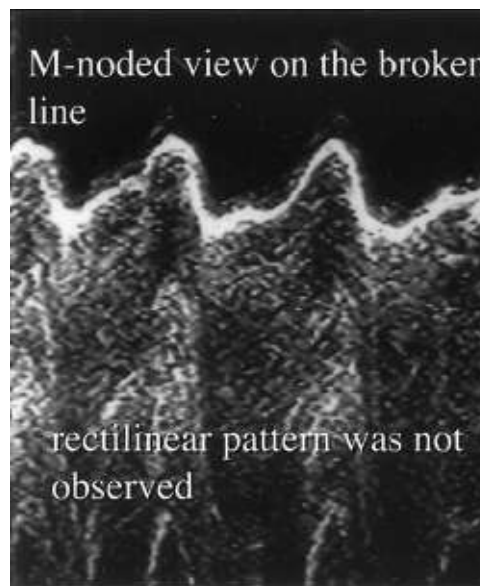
M-mode ultrasonogram of neonates with cleft palate. The rectilinear pattern was not observed.
